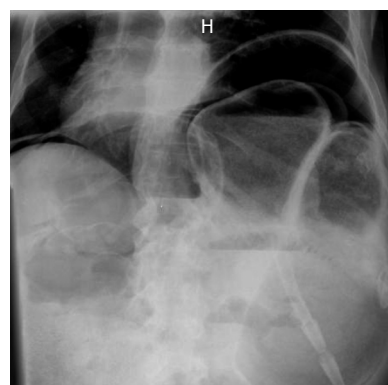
Abdominal plain X-ray showing a massive pneumoperitoneum.
